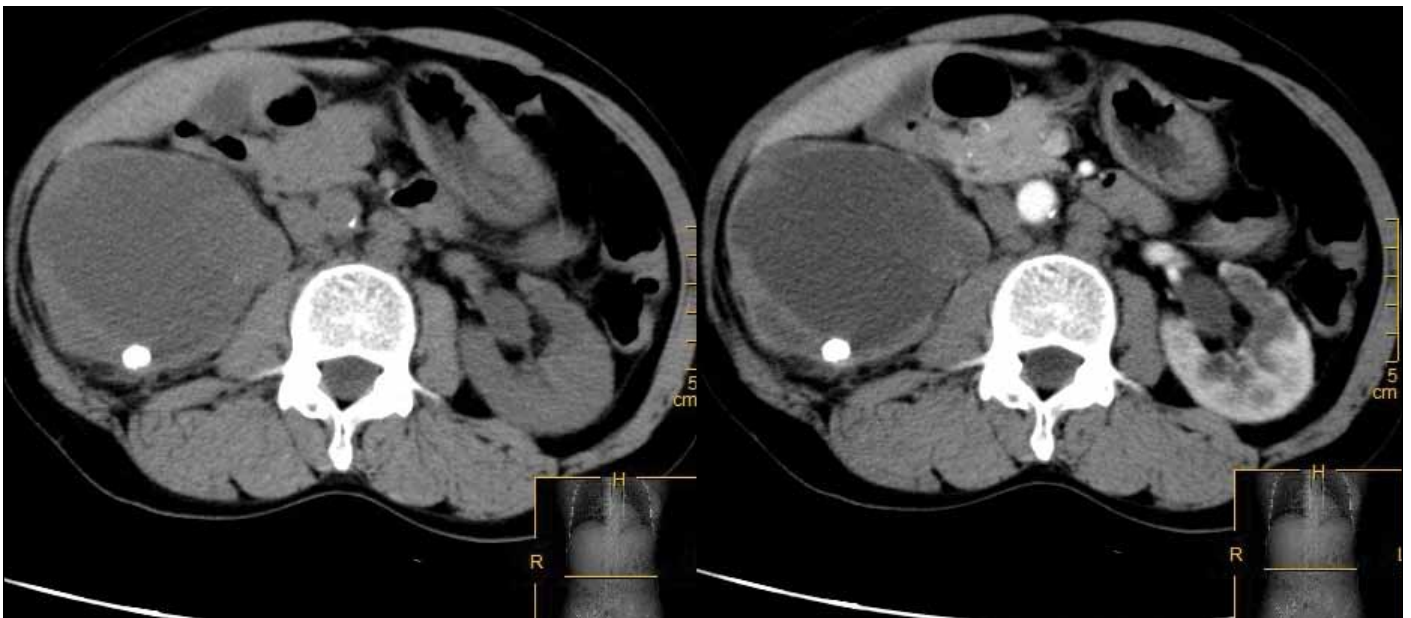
A computed tomography scan showing a 3 × 3-cm mass in the right renal pelvis.
